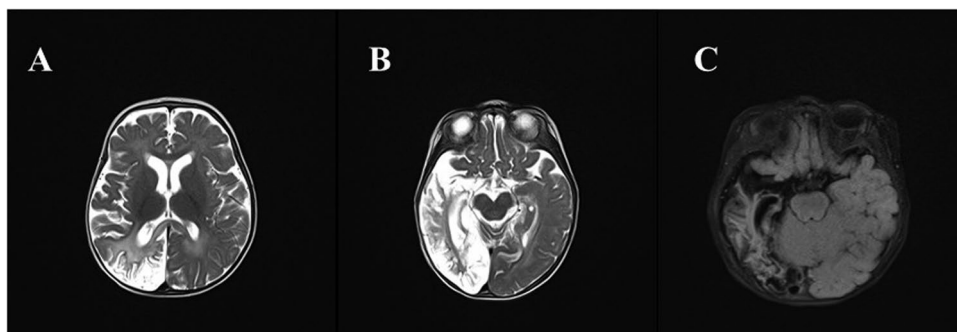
A–C. Axial T2 and FLAIR magnetic resonance imaging (MRI) showed signal hyper-intensity and atrophy predominantly in the right temporo-occipital lobes with the involvement of the cortex and the adjacent white matter.
